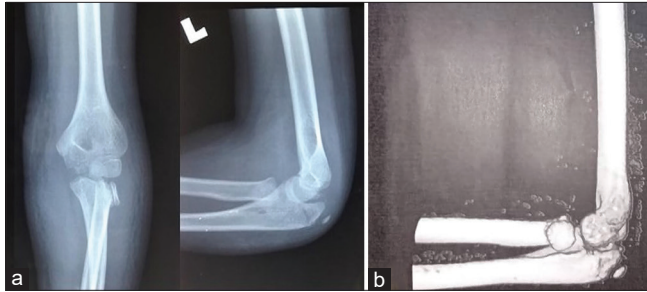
(a) Preoperative anteroposterior and lateral radiograph of the left elbow showing completely displaced radial neck fracture. (b) Preoperative computed tomography scan of the left elbow showing the position of the displaced radial head.
